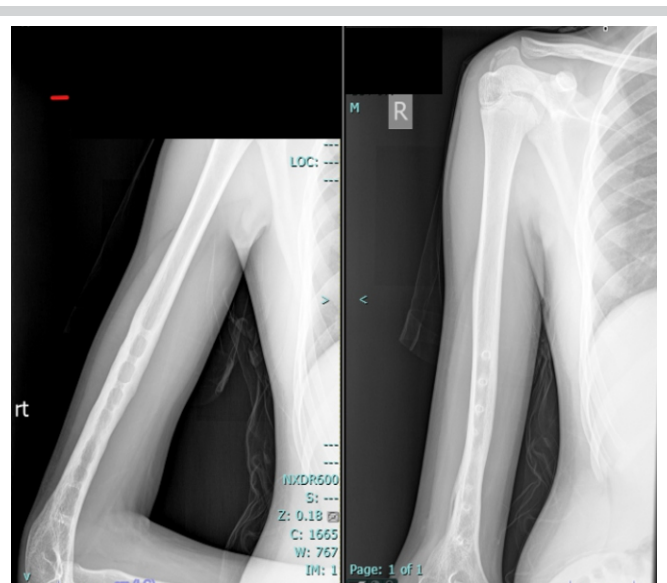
Radiograph at 6 months after low-intensity pulsed ultrasound showing complete union.
